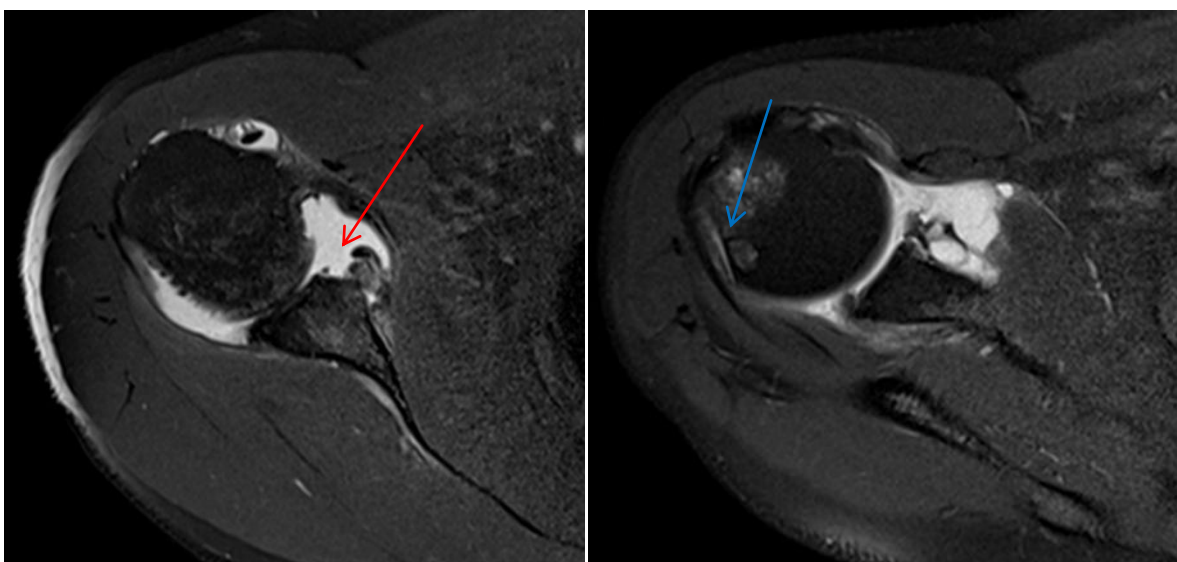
Above PD FAT SAT MR images show Hill-Sach's lesion (blue arrow) and bony Bankart lesion (red arrow) as described above.
